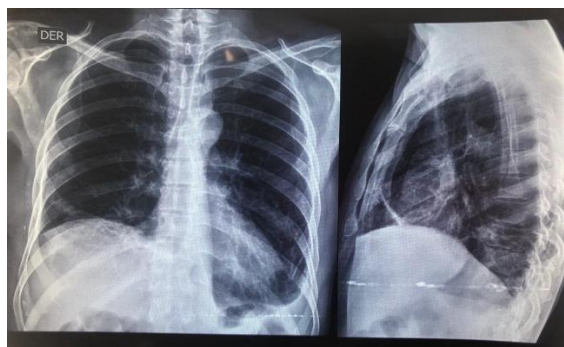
Chest X-ray showed no evidence of pleural effusion or pulmonary consolidation.
